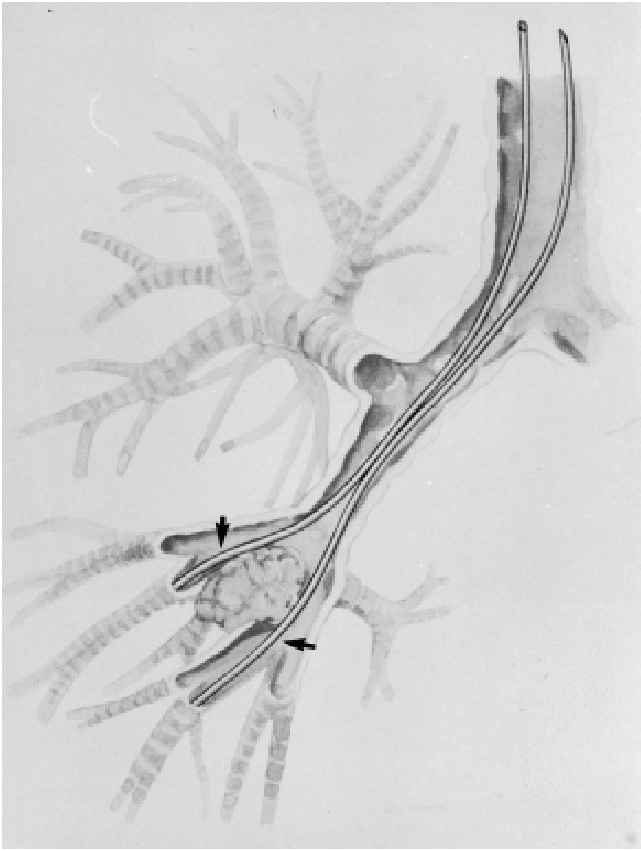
With bronchoscopic and radiographic guidance, flexible catheters (arrows) are advanced across and beyond the endobronchial lesion. (Courtesy of Nucletron, Columbia, MD, and with permission from Erickson B, Janjan N, Wilson JF: Brachytherapy: More versatile, more important for local control. *IM-Internal Medicine*, 1993;(14)5: 33-46, copyright Medical Economics Company.)
